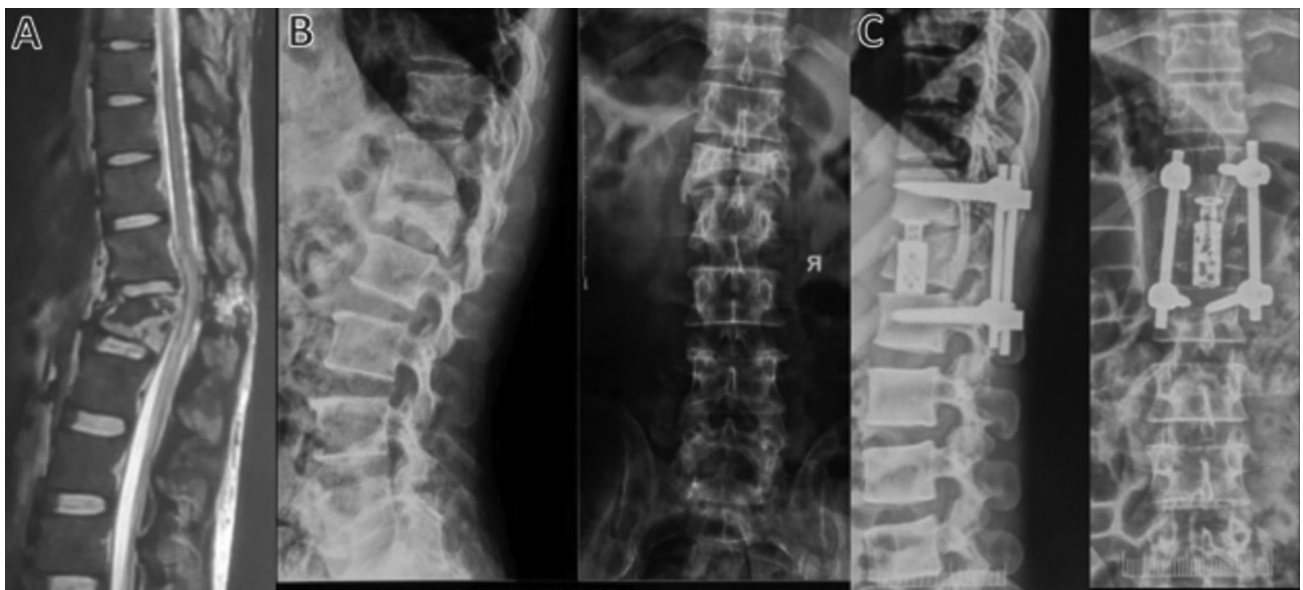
Combined decompression and stabilization through posterior only approach: (A) Preoperative magnetic resonance imaging, (B) preoperative X-ray, and (C) postoperative X-ray.
